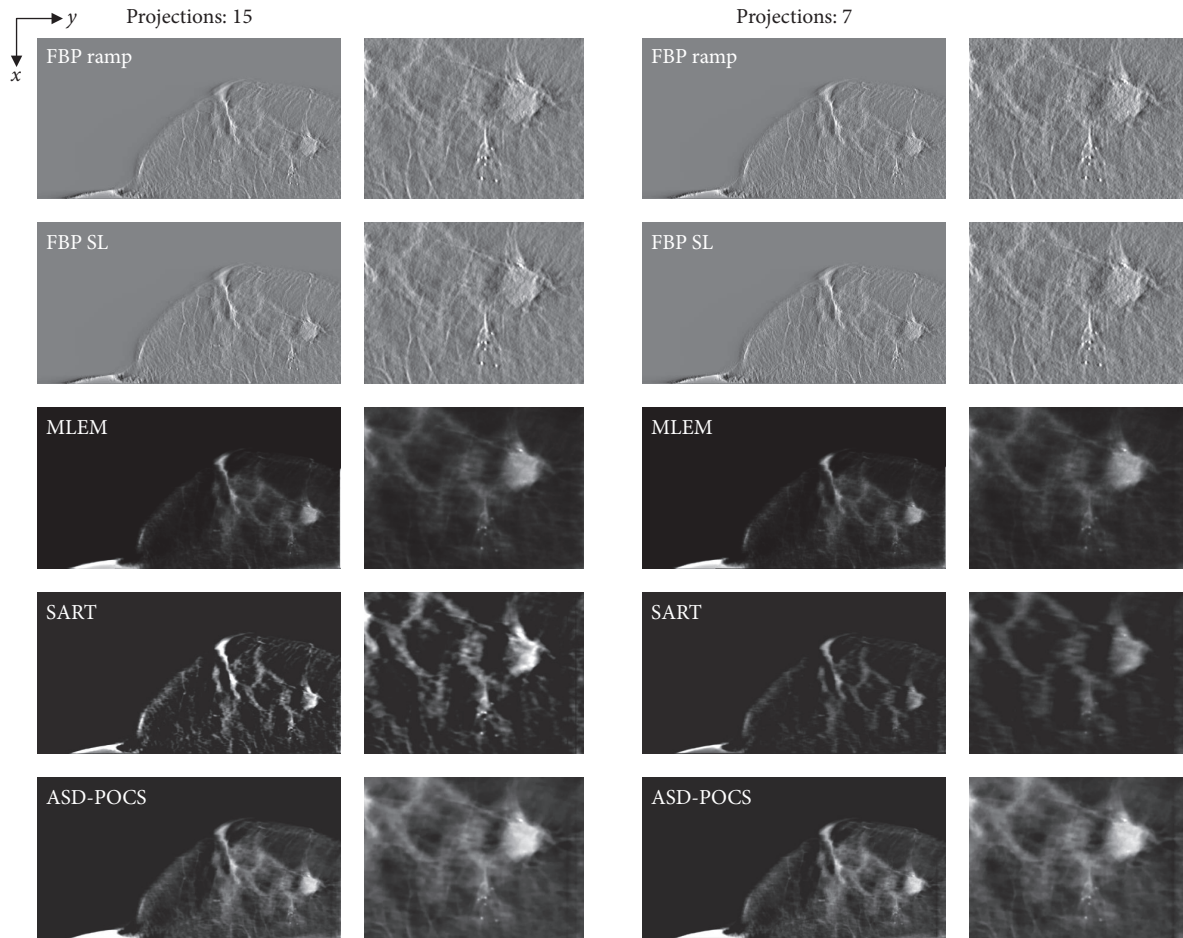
Case 3. Comparisons between images obtained at different projection numbers (normal: 15, half: seven) using each tomosynthesis reconstruction algorithm in the in-focus plane. The X-ray source was moved horizontally along the image. Zoomed images depict the lesion areas. For each corresponding set, IR (MLEM, SART, and ASD-POCS) images are displayed at the same window width and level, whereas the FBP images have a larger window widths because the backgrounds are less flattened and the gray levels in larger areas would be out of scale in narrower windows.
